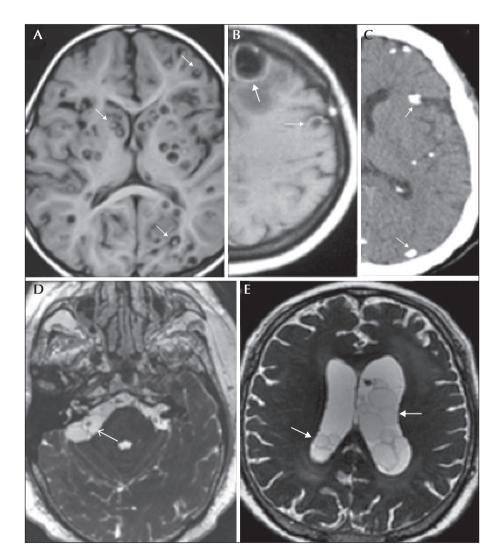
Imaging of parenchymal and extraparenchymal neurocysticercosis. (A) T1-weighted MRI showing viable multiple parenchymal cysts with scolex (arrows). (B) T1-weighted MRI showing degenerative-colloidal cysts (arrows). (C) CT showing multiple parenchymal calcifications (arrows). (D) 3D MRI sequence (FIESTA) showing cysticerci at the cerebellopontine cistern (arrow). (E) 3D MRI sequence (FIESTA) showing cysts inside the ventricles (arrows).
